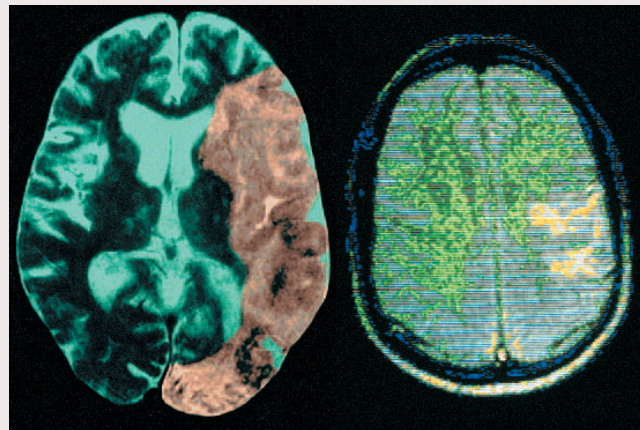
Figure B MRI of a massive stroke in the brain (left). Colorized NMR showing disruption of blood flow to the right side of the brain (yellow). This disruption could cause a stroke (right).
